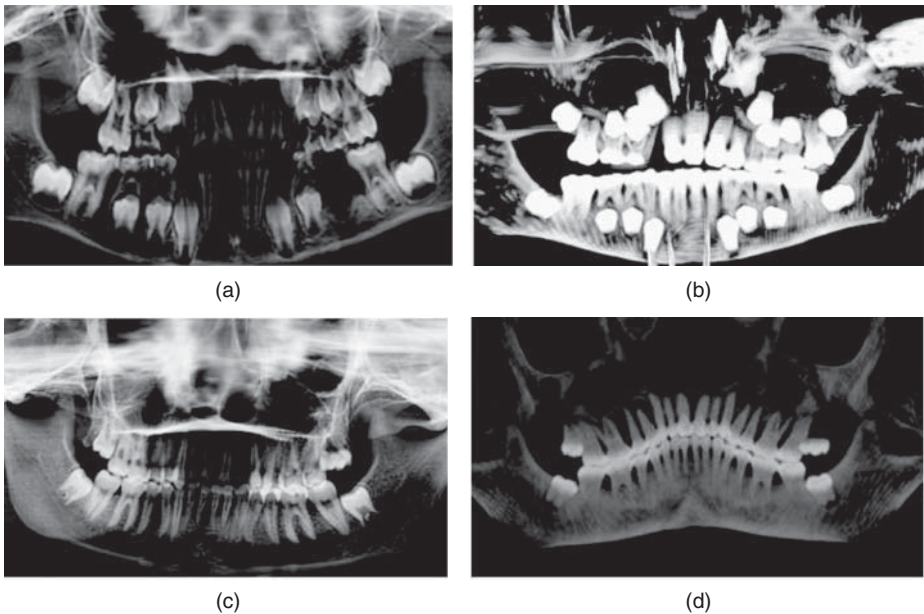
Two sets of matched orthopantomogram (OPT) and multi-detector CT (MDCT) 3-dimensional curved multi-planar reconstruction (MPR) images: (a) aged 8–10 years, traditional dental OPT; (b) aged 8–10 years, MDCT 3-dimensional curved MPR (mean intensity projection); (c) aged 18–21 years, traditional dental OPT; (d) aged 18–21 years, MDCT 3-dimensional curved MPR (maximum intensity projection). Research images courtesy of Alison Brough, East Midlands Forensic Pathology Unit, Leicester
